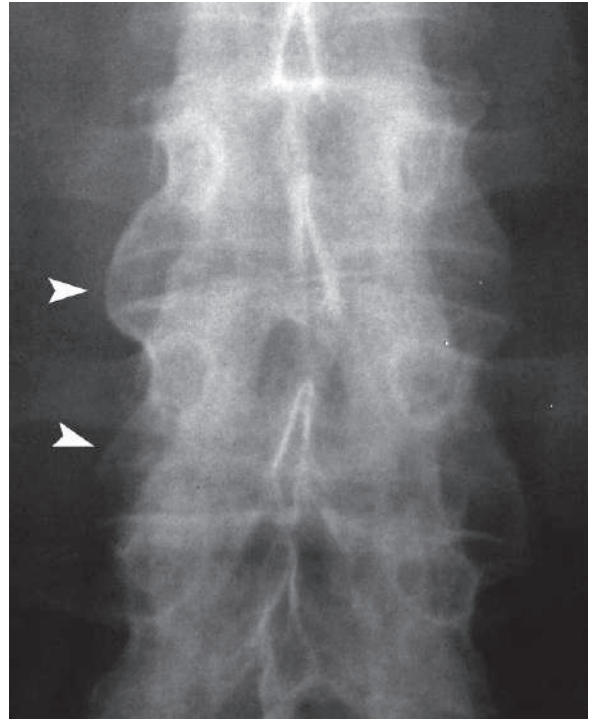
Anteroposterior plain radiograph of the thoracic vertebrae shows syndesmophytes (*arrowheads*)
